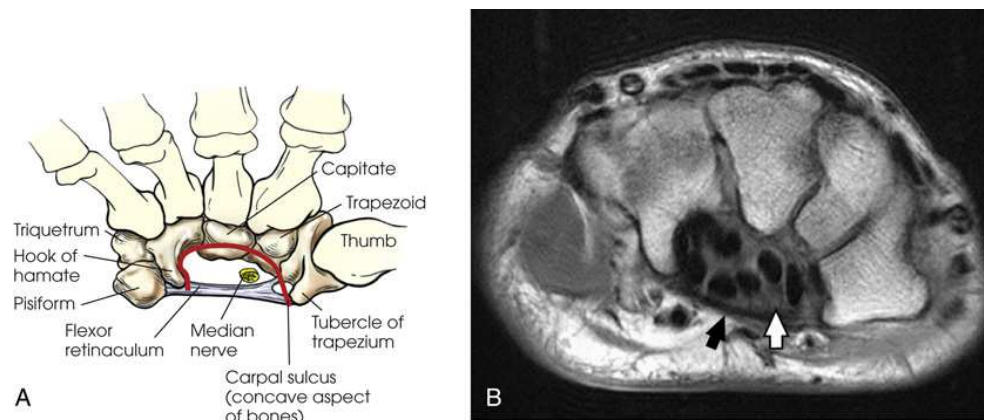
(A) Carpal sulcus. (B) Axial MRI of wrist. Bones in same position as in Fig. 5.3A. Note arched position of carpal bones and carpal sulcus protecting tendons of fingers (*black circles* within sulcus) and median nerve (*white arrow*). Flexor retinaculum (*black arrow*) is also seen.
